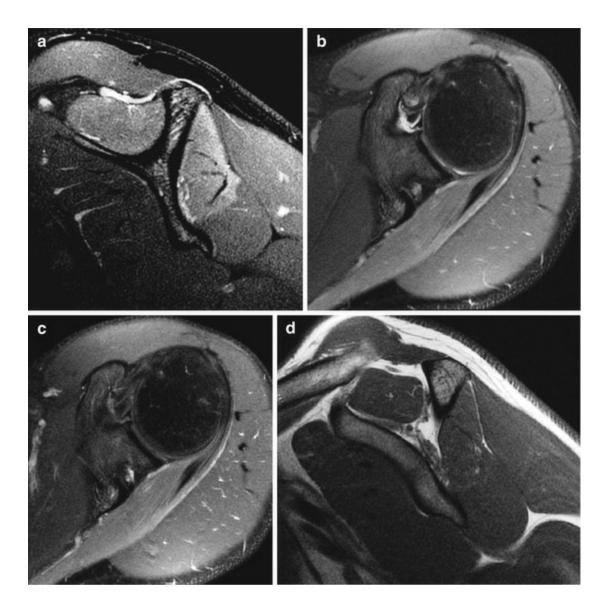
Suprascapular neuropathy at the scapular notch in a 27-year-old patient. Sagittal (a) and axial (b) fat-suppressed T2-weighted MRI show edema of the supraspinatus and infraspinatus muscles. (c) Axial contrast-enhanced fat-suppressed T1-weighted MRI shows a homogeneous enhancement of the infraspinatus muscle. (d) Sagittal T1-weighted MRI shows muscle atrophy and signal increase of the supraspinatus and infraspinatus muscles
